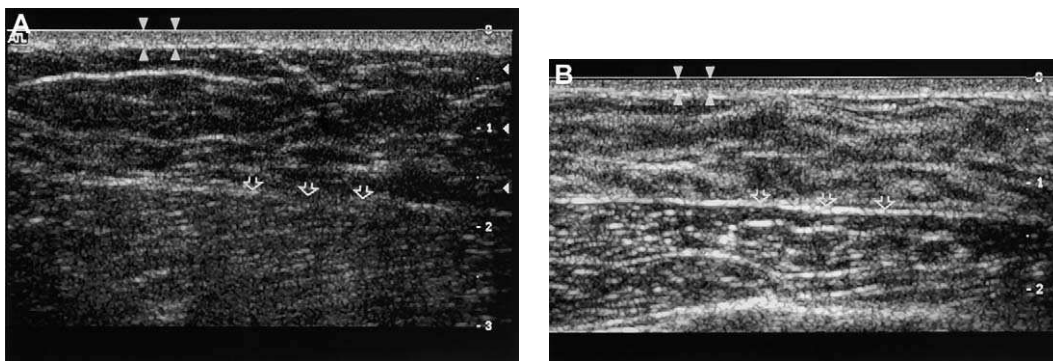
Normal breast ultrasound. Arrowheads denote normal skin, and open arrows denote the interface between the breast tissue and pectoralis muscles in a diffusely fatty (A) and diffusely dense (B) breast.
